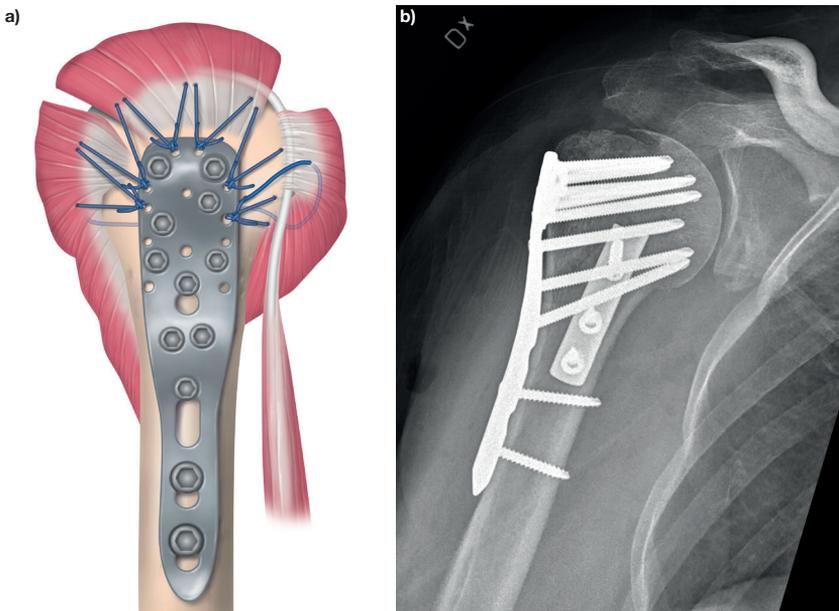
a) Lateral view of an anatomical plate for PHFs, with additional sutures securing the tubercles. b) Post-operative radiograph of a four-part PHF fixed with an anatomical plate and an additional mini PHF fixed with a mini plate for medial support.
